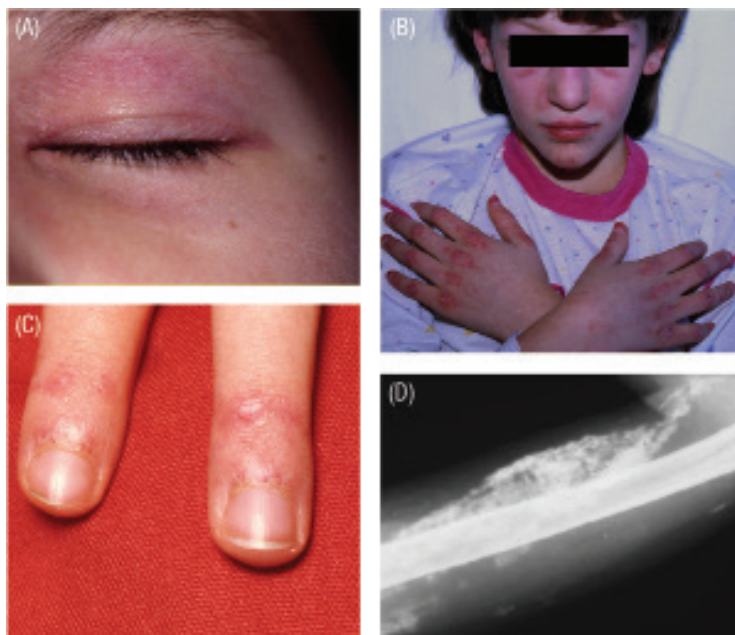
(A) Heliotrope rash: purple discoloration above the eyelids sometimes associated with periorbital edema. (B) Facial erythema may occur in a malar distribution. Gottron papules: erythematous papules and patches overlying the finger joints and other extensor surfaces, including the elbows and knees. (C) Nailfold capillaropathy. (D) Calcinosis as seen on x-ray.
